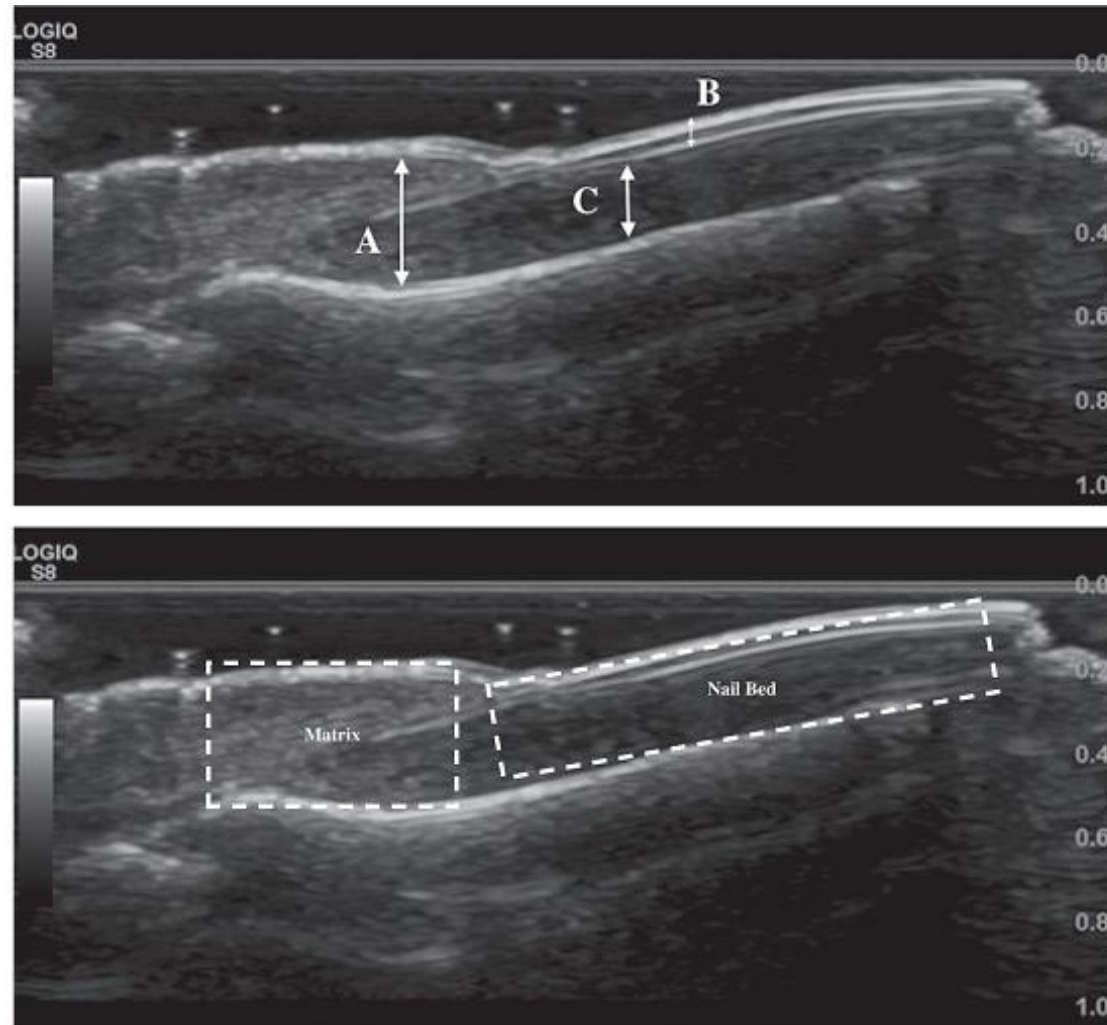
(A) Areas of morphologic changes in the nail. (B) Areas (nail bed and matrix) to assess for power Doppler signaling. A: measurement of the thickness of the nail matrix; B: assessment of the morphologic changes of the nail plate; C: measurement of nail bed thickness.
